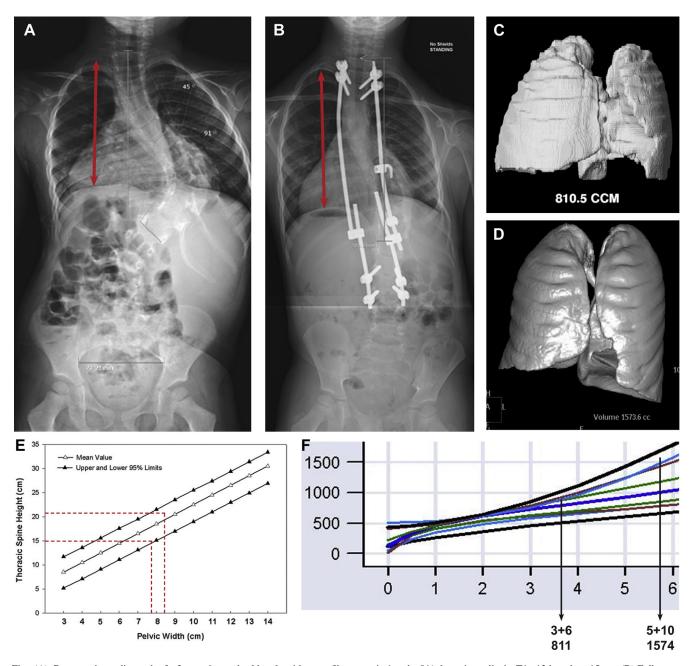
(A) Preoperative radiograph of a 3-year 6-month-old male with neurofibromatosis-1 and a 91° thoracic scoliosis. T1-12 length = 15 cm. (B) Follow-up radiograph at age 6 years. Curve correction to 49° and T1-12 length = 20.9 cm. The space for the concave lung is clearly enlarged. (C) Preoperative CT lung volume = 811 mL, corresponding to (A). (D) Follow-up lung volume, corresponding to (B) = 1,574 mL. (E) T1-12 length, normalized for pelvic width [2]. Preoperative length (15 cm) has increased from the fifth to approximately the 60th percentile (20.9 cm), which suggests that length gain has exceeded what would be predicted from normal growth. (F) Computed tomography volumes normalized for age [4]. Because of the narrow differences between percentiles in very young children, accurate documentation of percentile change with volume increase is uncertain.
